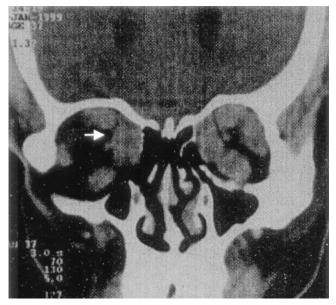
Coronal computed tomographic scan of the orbits demonstrating marked enlargement of the medial rectus (arrow) in the right eye and marked enlargement of all extraocular muscles in the left eye.
